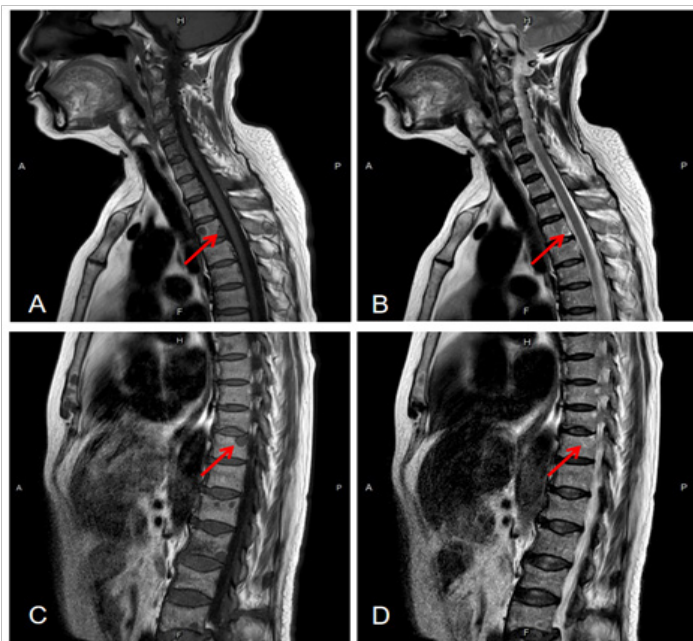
Spinal magnetic resonance imaging (MRI) examination showing multiple vertebral lesions (arrows), low signal on T1-weighted images (A, C) and high signal on T2-weighted images (B, D)
